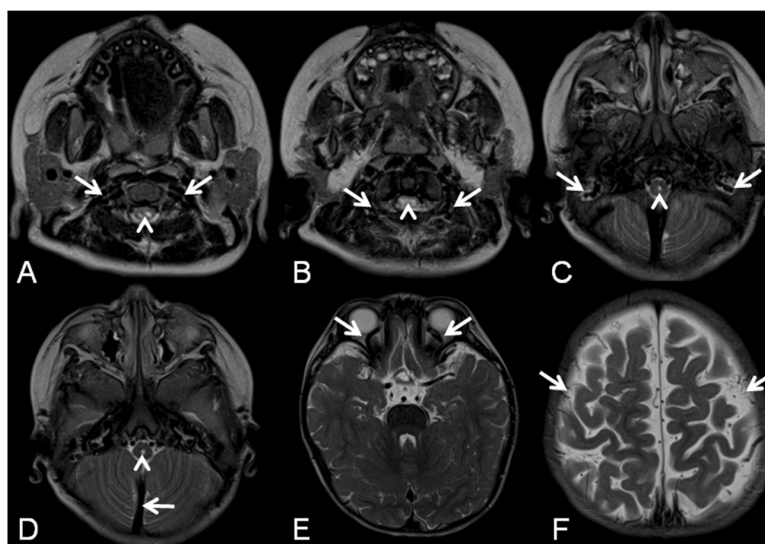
Axial T2-weighted images of a 22-month-old girl with achondroplasia showing a bilateral condyloid emissary veins (arrows) and T2-hyperintense signal in the cervical cord consistent with myelomalacia (arrowhead); b bilateral occipital emissary veins (arrows) and T2-hyperintense signal in the cervical cord consistent with myelomalacia (arrowhead); c bilateral mastoid emissary veins (arrows) and central
